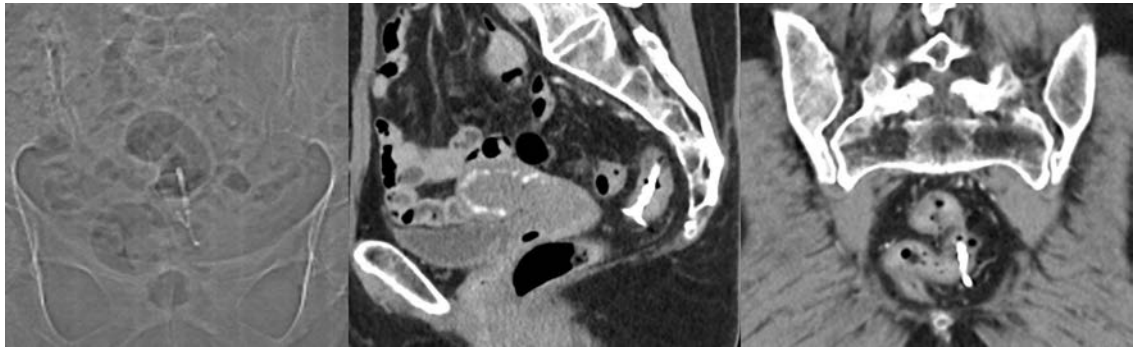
CT scan revealing the location of the intrauterine device with one stalk in the lumen of the rectum and the rest of the device in the mesorectum, unrelated to the uterus, below the peritoneal reflection.
